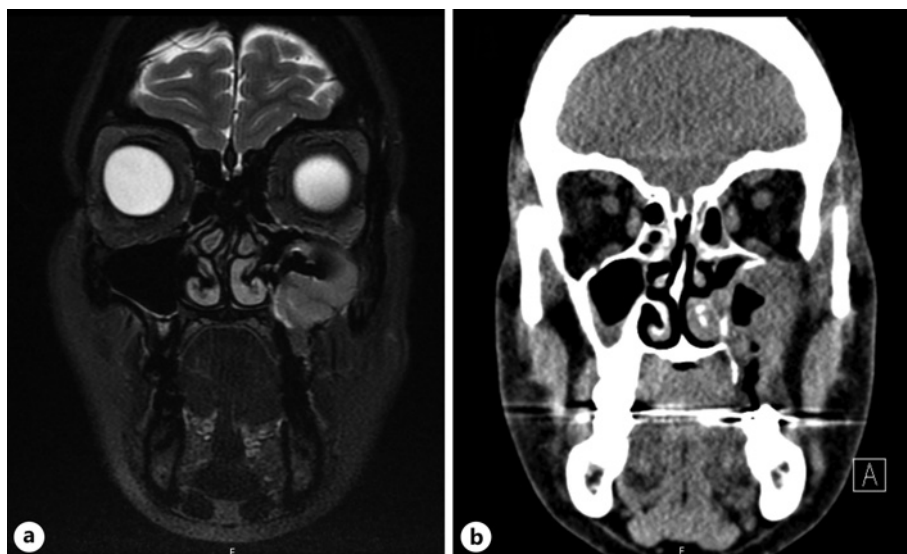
Imaging at original presentation. a T2 MRI orbits with abnormal enhancing tissue that is T2 hypointense with restricted diffusion in the left maxilla and left maxillary sinus, consistent with neoplasm. b Maxillofacial CT scan demonstrates soft tissue density extending into the left maxillary sinus and correlates with enhancing tissue seen on MRI. There is associated multifocal thinning and erosion of the posterior and lateral walls of the left maxillary sinus, inferolateral left orbit, and involvement of skull base foramina without intraorbital or intracranial extension.
